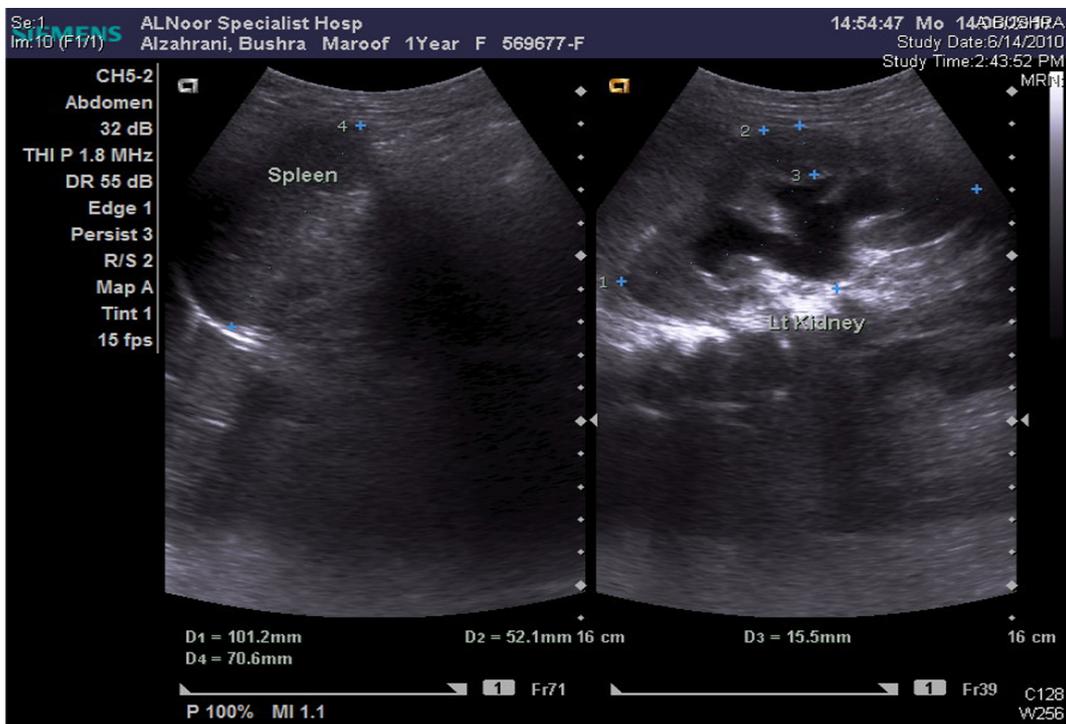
Ultrasound of kidney - 2.
